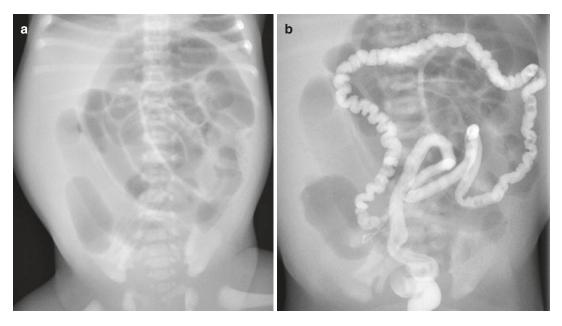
Ileal atresia. (a) Plain abdominal radiograph demonstrates multiple dilated bowel loops consistent with a distal bowel obstruction. (b) Water soluble contrast enema demonstrates a microcolon
